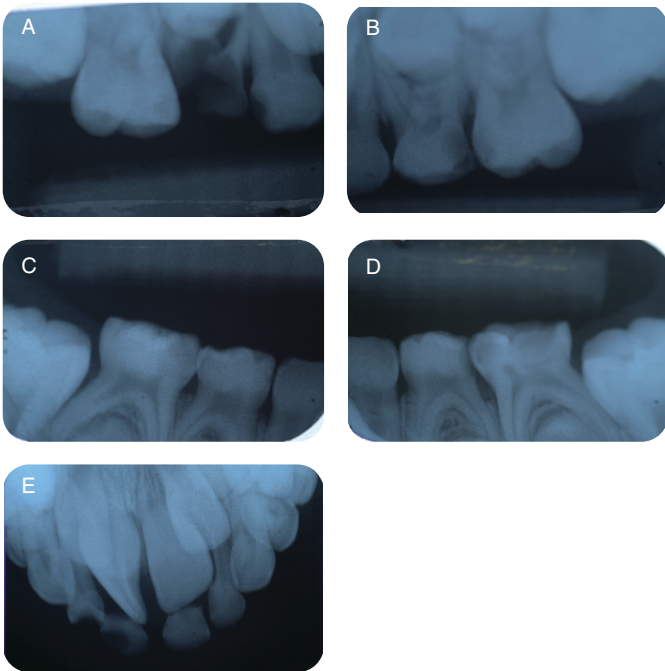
Pre-op radiographs. A. maxillary right periapical radiograph, B. maxillary left periapical radiograph, C. mandibular right periapical radiograph, D. mandibular left periapical radiograph, E. Maxillary occlusal radiograph
